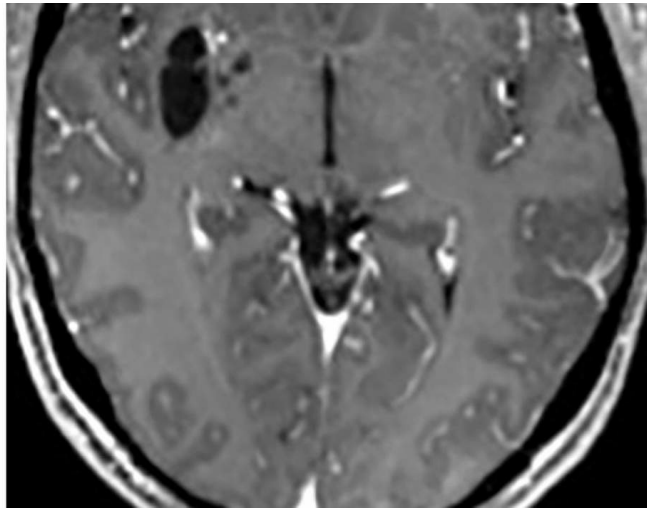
Large oval structure within the right putamen that follows CSF signal intensity on T1-weighted (top left), T2-weighted (top right), FLAIR (middle left), and DWI (middle right) imaging. Notice that there are a few additional smaller similar-appearing cystic structures medially, also representing dilated perivascular spaces. There is no significant adjacent FLAIR signal abnormality (middle left) or enhancement (bottom) to suggest an alternative diagnosis.
